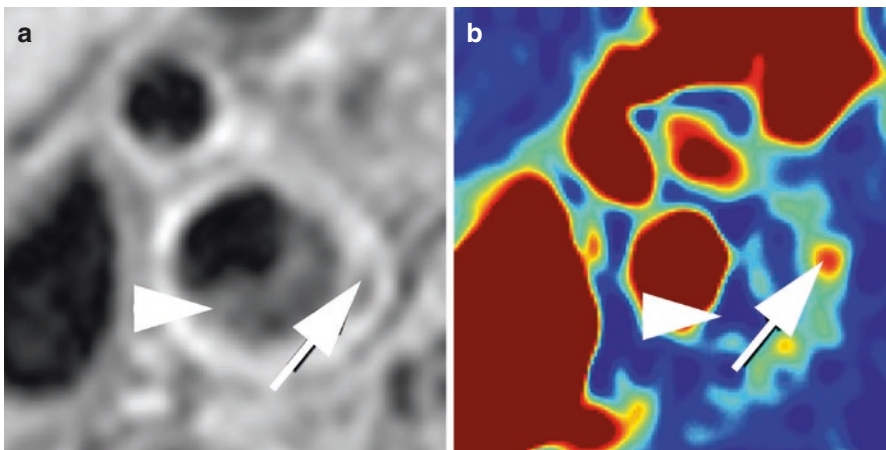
Carotid plaque dynamic contrast enhanced MRI. Carotid plaque dynamic contrast enhanced (DCE)-MRI can allow quantification of plaque neovessel density and permeability. One DCE metric is the contrast transfer constant K^{trans} , which is a measure of tissue blood flow (F_p) and capillary permeability-surface area product (PS_p). In this 3D T1-weighted image (a) of a left carotid plaque, there is a large central lipid core (arrowhead) and a rim of higher signal along the adventitia (arrow). Corresponding DCE-MRI K^{trans} map shows elevated K^{trans} along the periphery (arrow), and this correlates with microvessel density, macrophage density and vulnerable plaque features such as IPH
